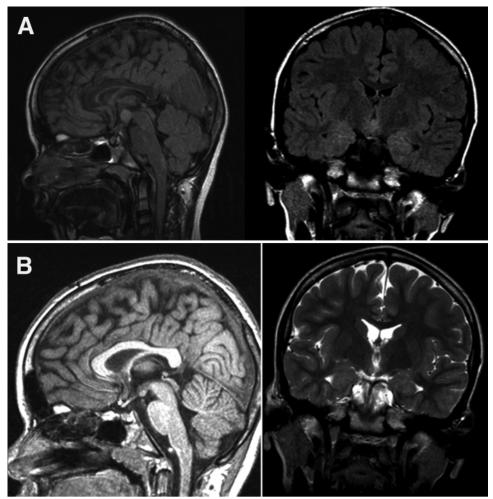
Magnetic resonance images obtained in a 9-year-old boy with GE since infancy, generalized seizures, and severe cognitive and behavioral dysfunction. The patient had a > 90% improvement in seizures and behavior after endoscopic resection. Memory improved from severe dysfunction to average function. Sagittal (A) and coronal (B) FLAIR images showing an intra-HH. Postresection sagittal FLAIR (C) and coronal T2-weighted (D) MR images demonstrating residual lesion.
